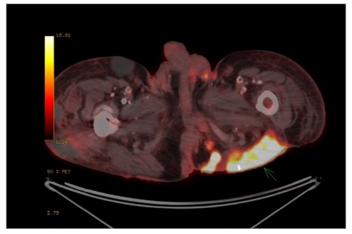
PET-CT image showing a metabolically active lesion in the left buttock suggestive of malignancy.
